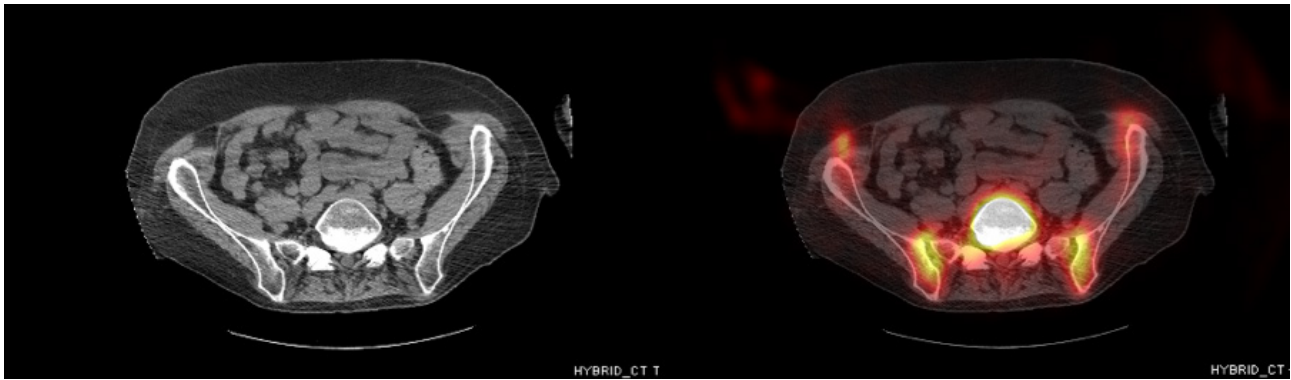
CT and fused bone SPECT/CT image of the pelvis area showing motion of the pelvis and hand, and truncation of the opposite hand and slight truncation of the right pelvis (left side).
